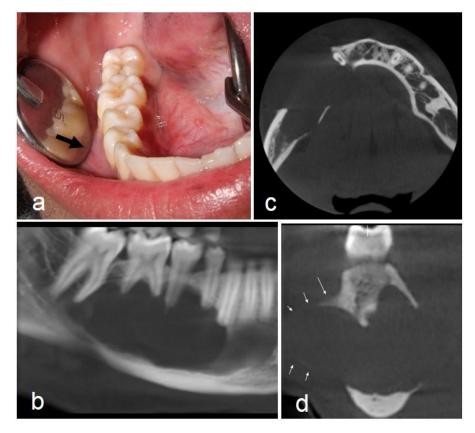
Pre-op intraoral photograph; 1b. CBCT sagittal view showing inferior displacement of the nerve canal and external root resorption of the mandibular teeth showing loss of buccal and lingual cortical bone; 1c. CBCT axial view; 1d: Oblique coronal view showing alveolar bone destruction, cortical bone expansion and thinning
